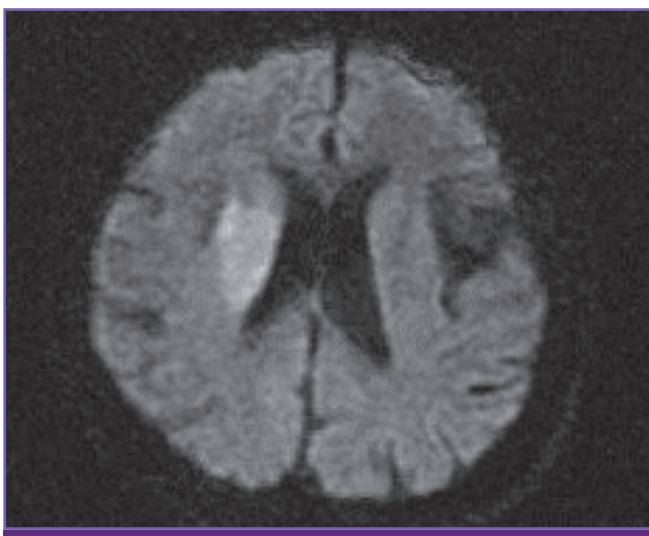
MRI axial diffusion weighted image of brain shows an infarction involving right basal ganglia, periventricular white matter, and basal temporal lobe. MRI, magnetic resonance imaging.
